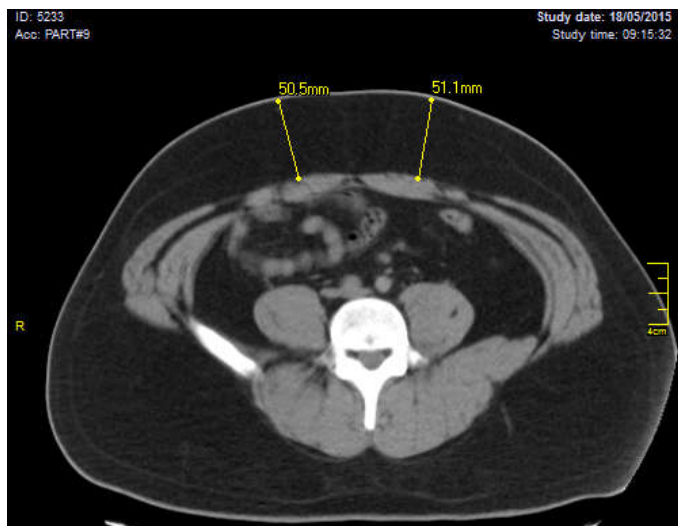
Patient caliper measurement was 6.3 cm, related to 50.5 and 51.1 mm CT scan measurements
